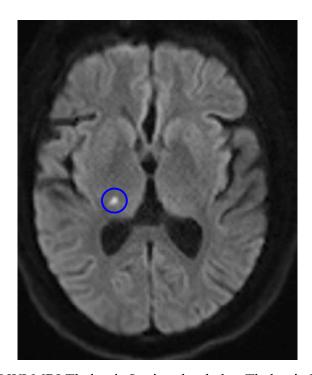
T2 DWI MRI Thalamic Lesion that led to Thalamic Pain Syndrome
